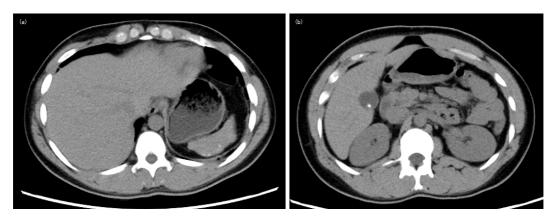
Transverse computed tomography without contrast medium on the day of presentation. The images show a relatively small spleen with multiple small calcifications (a) and a calcified gall stone (b).
